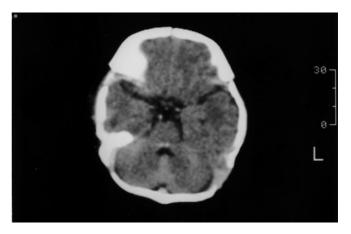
Computed tomography (CT) scan of a pontine section at 1 month of age. Minute calcifications are seen on the fourth ventricle floor
